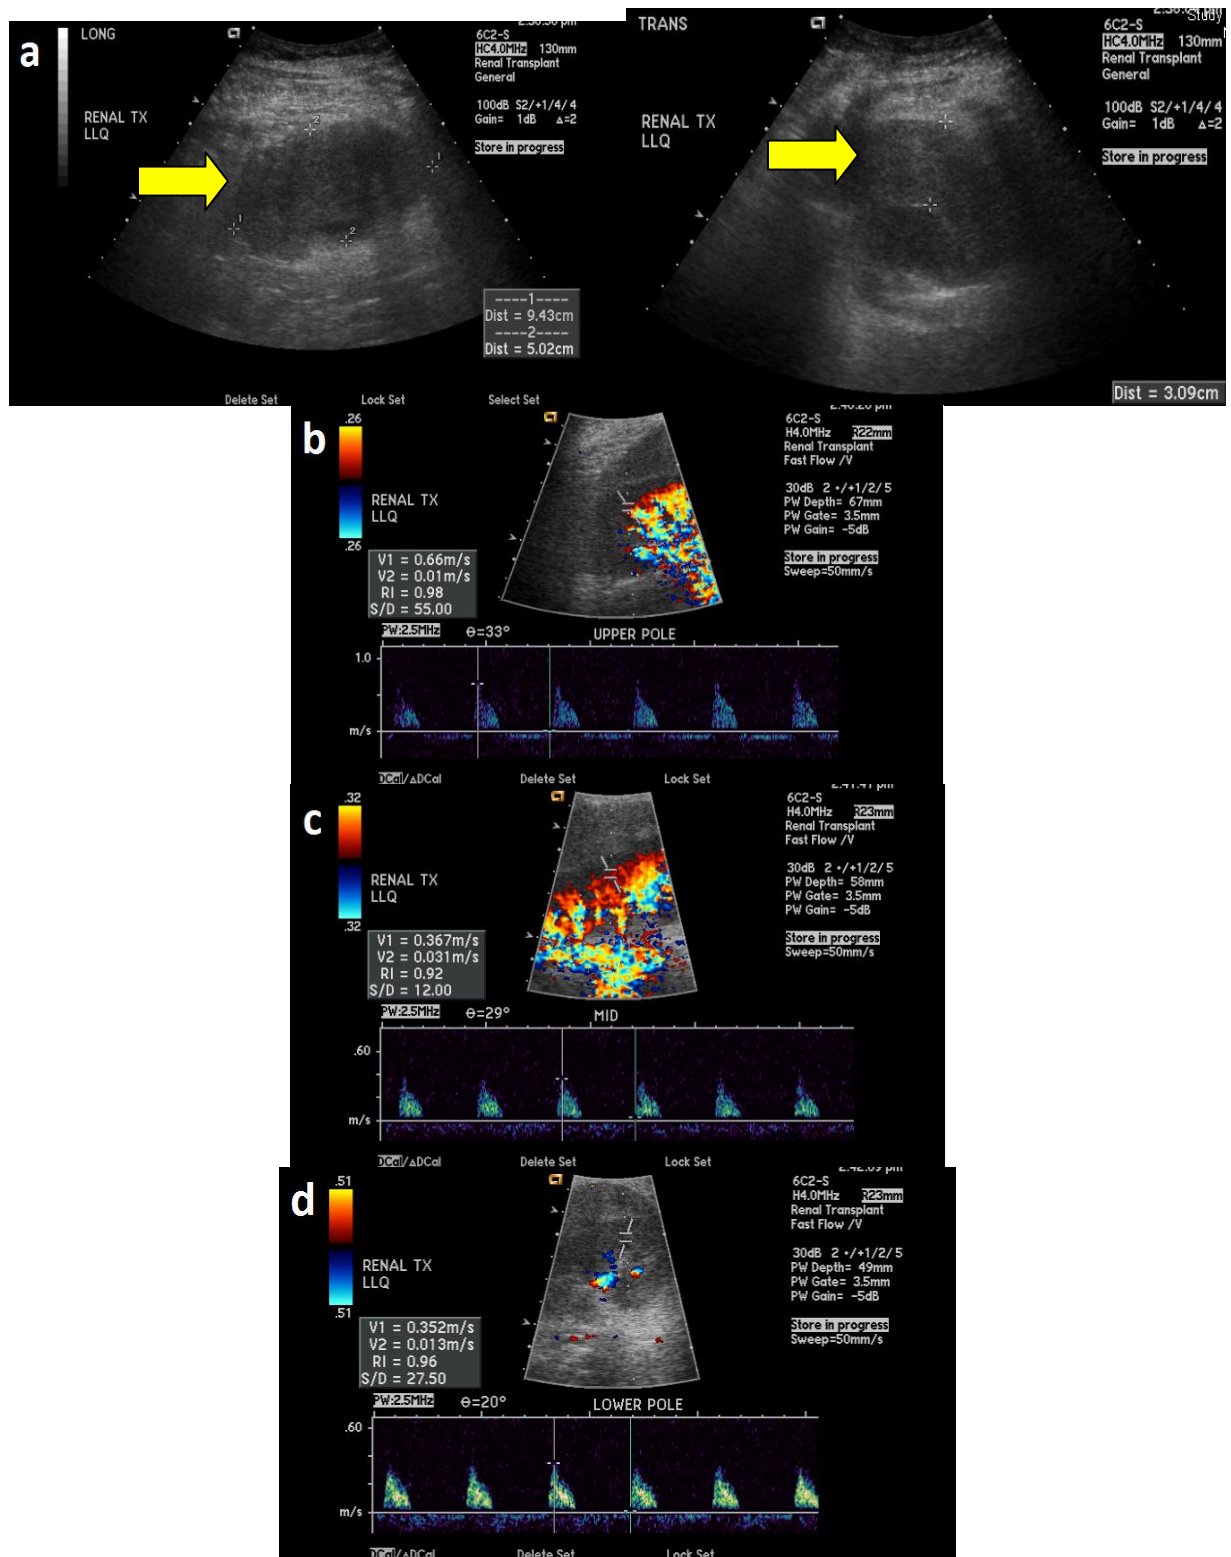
Transplant kidney ultrasound showing a large subcapsular perinephric concentric hematoma (a: marked by crosses and yellow arrows). Doppler studies showed increased resistive indices on the upper (b), middle (c), and lower (d) poles of the kidney.
